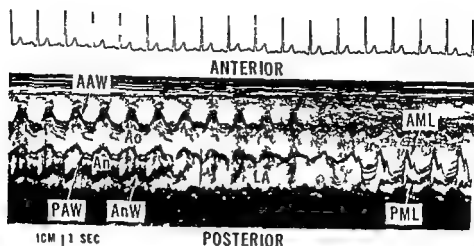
Standard echocardiogram demonstrating a sweep from mitral valve to aorta. A dense line of echoes representing the aneurysm wall (AnW) is noted posterior to the aorta (Ao). AAW = anterior aortic wall; AML = anterior mitral leaflet; An = aneurysm; LA = left atrium; PAW = posterior aortic wall; PML = posterior mitral leaflet.
